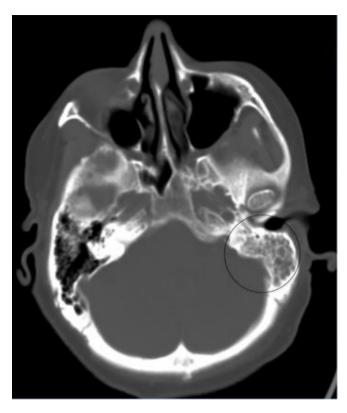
Computed tomography angiography of the head and neck demonstrates complete opacification of the left mastoid air cells as well as left temporal pneumocephalus (circle) suspicious for acute otomastoiditis.
